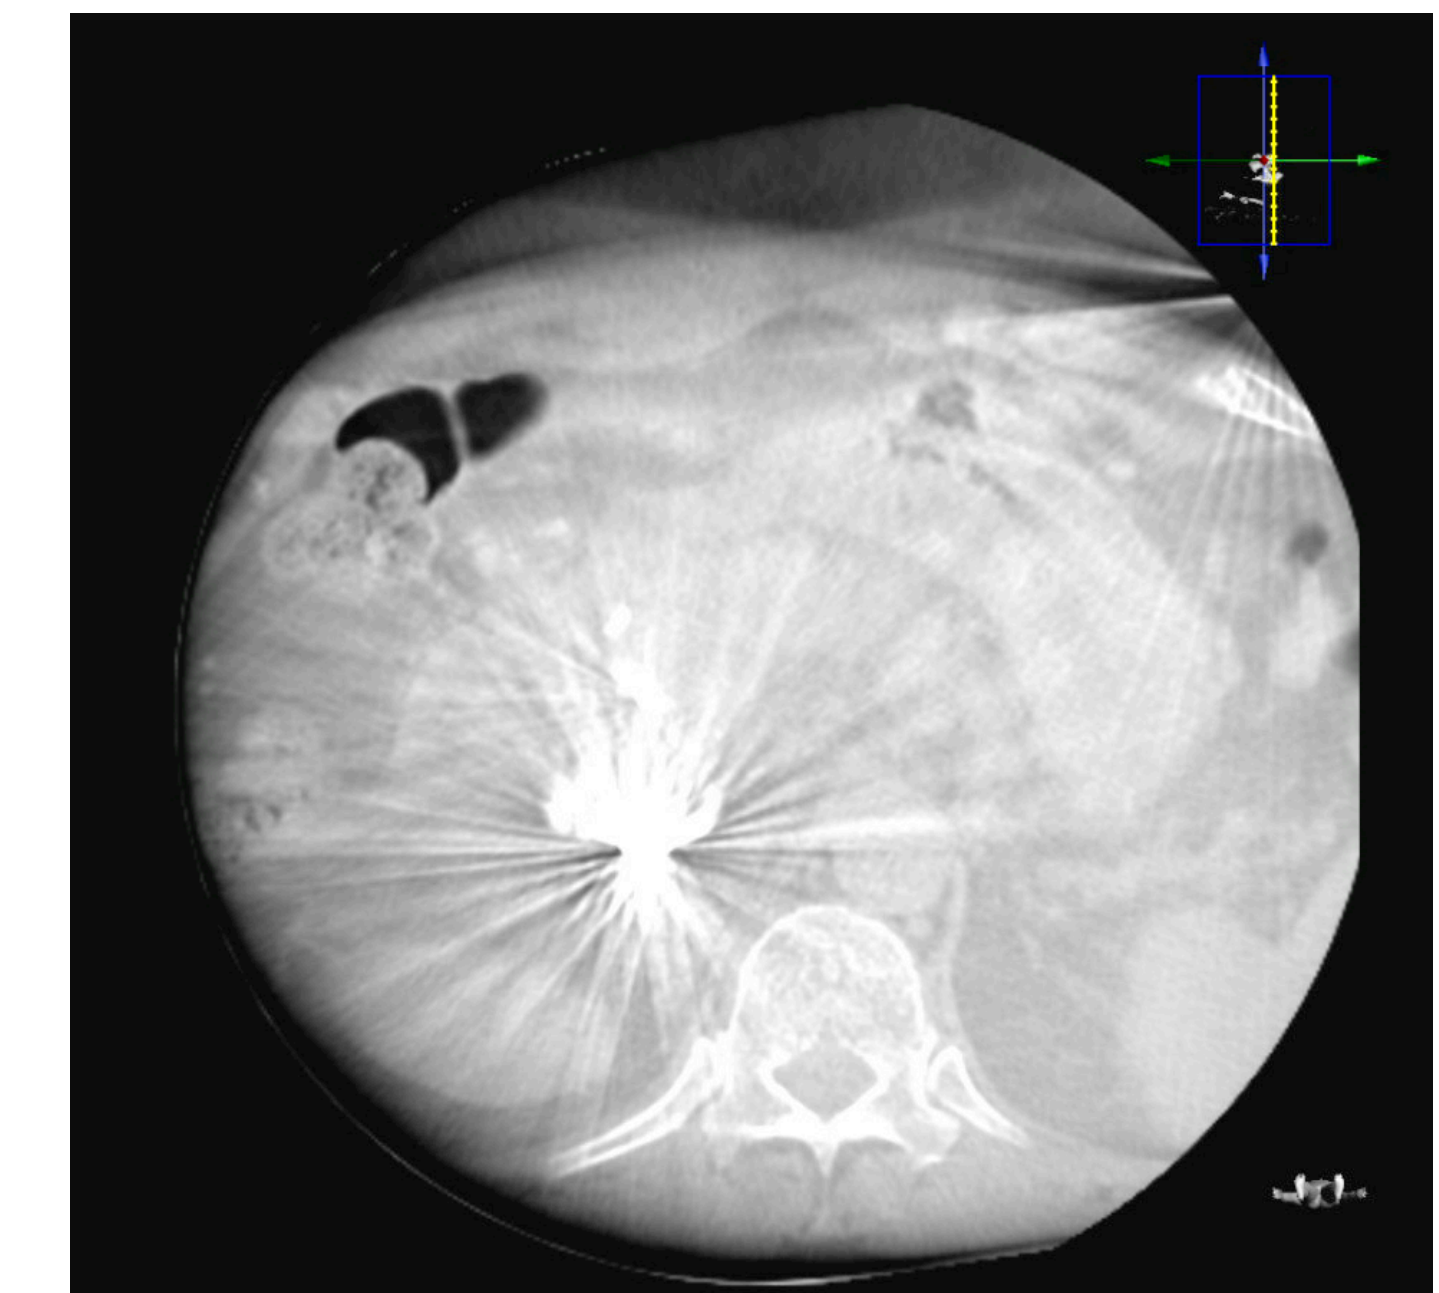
Cone-beam CT demonstrating Onyx-18 liquid embolic at the site of the PSA.
